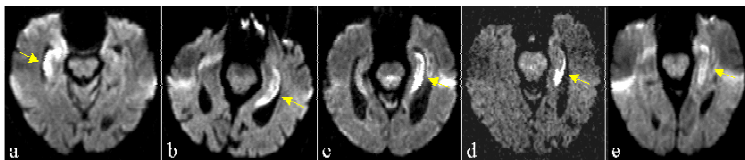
Diffusion-weighted MRI depicting involvement of the dorsal medial thalamic structures in patients 2, 4, 5, 13 and 14 (left to right) in almost identical areas across the five patients (yellow arrows). Extratemporal cortical hyperintensity in patients 2 and 5 is to be appreciated (green arrow).
